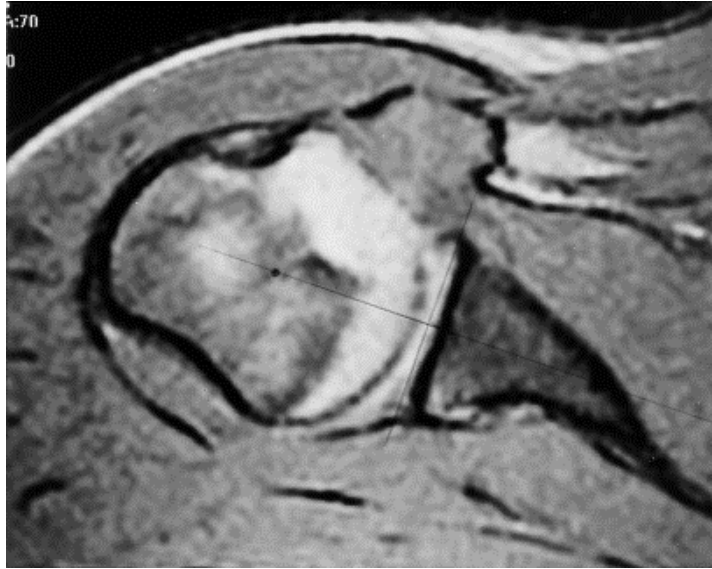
MRI scan showing markings for the humeral head center and perpendicular bisector of the glenoid used to measure anterior or posterior translation of the humeral head from the glenoid center. In this position, the humeral head is precisely centered.
